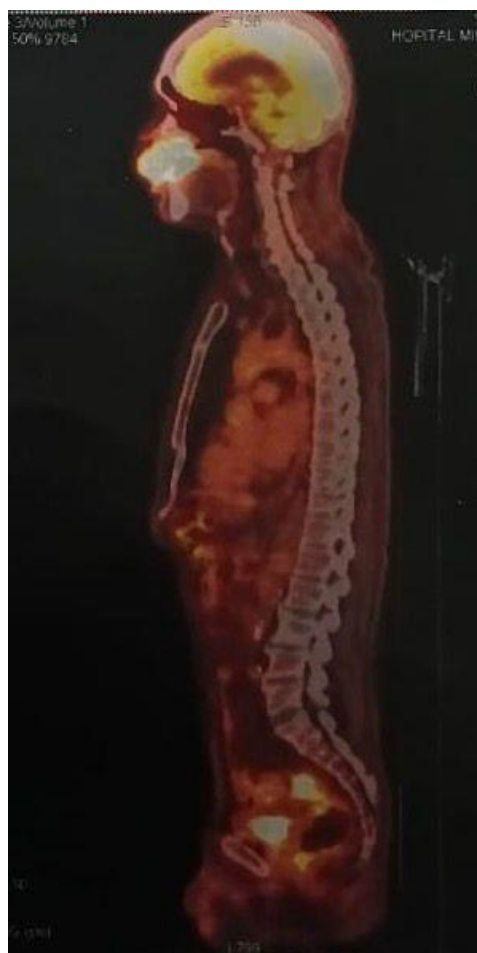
PET-CT scan showing hypermetabolic right maxillary mass and rectosigmoid thickening
